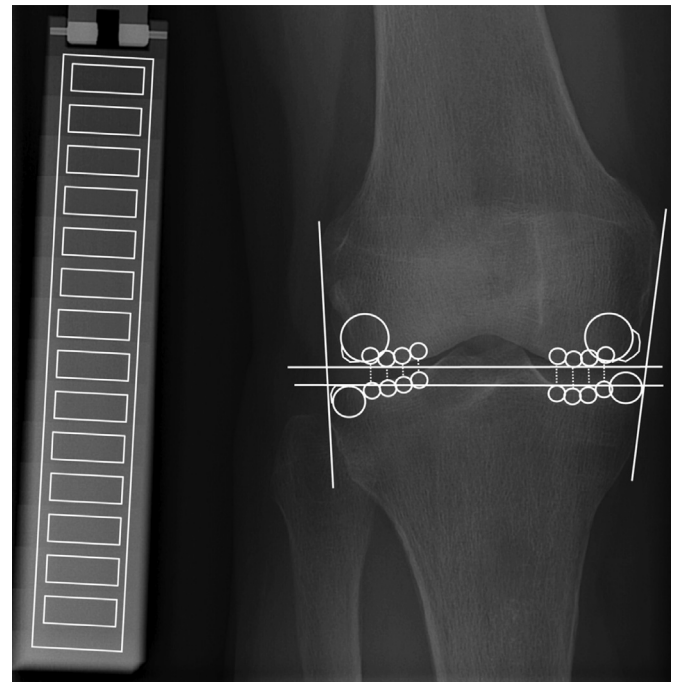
Screenshot of KIDA. Small and larger circles are positioned in relation to a framework demarcating the knee joint. The framework and circles are positioned automatically, but their positions can be adjusted manually. JSW is assessed between the small circles aligning the bone–cartilage interface (dotted lines). Osteophyte area is determined outside the larger circles positioned at the corners of the lateral and medial femur and tibia. Bone density is assessed within the small circles, by normalization to an aluminum step wedge (rectangle) included on all radiographs. For details see references 10 and 12.
